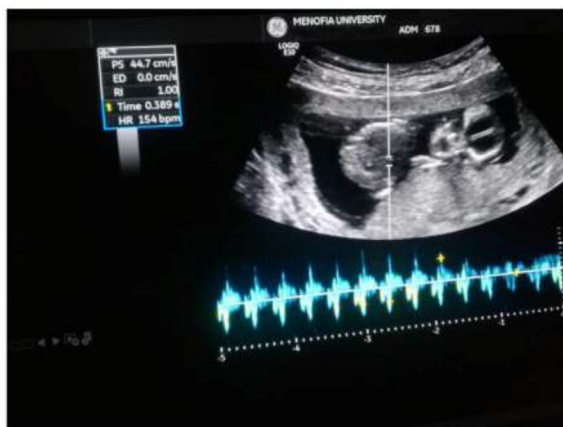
FHR at the 12th week of gestation measured by Doppler method. FHR, fetal heart rate.
